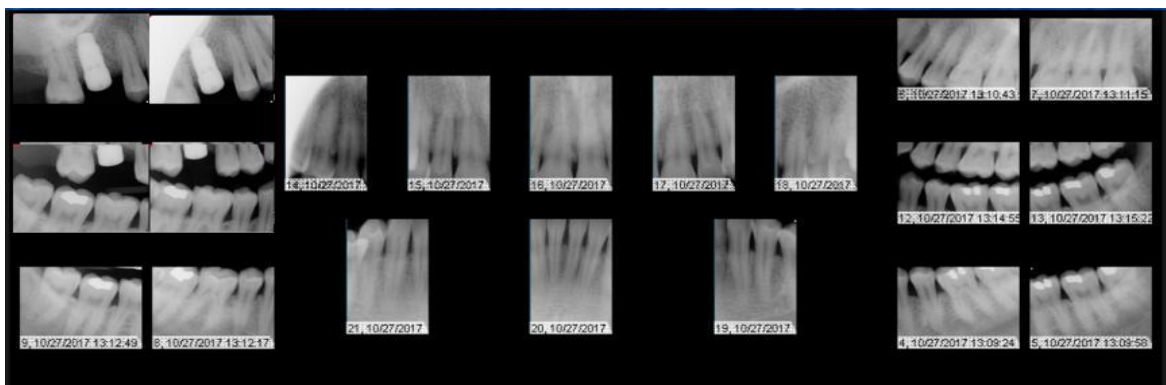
Various Radiographs
